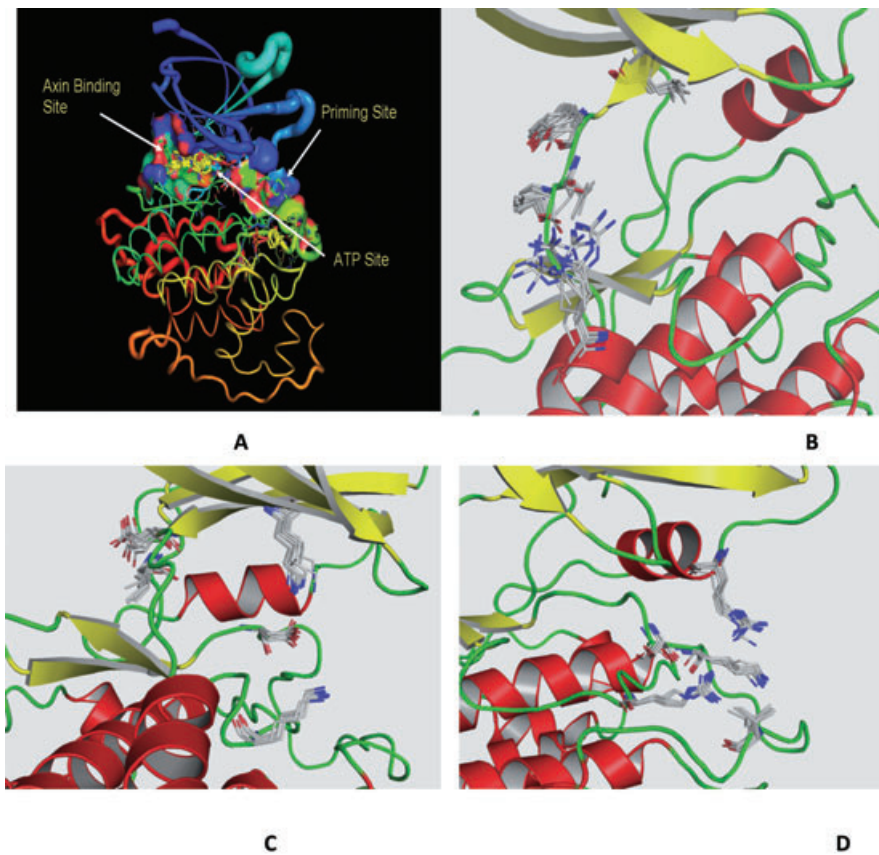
Different binding pockets of GSK3 β . (A) Overlay of X-ray structures at C α depicting different binding sites for GSK3 β ; (B) ATP site; (C) axin binding site; (D) priming site. The residues of each site are overlaid to understand the mobility of each residue. The helices are denoted in red, β -sheets in yellow and loops in green colour. The residues are shown in elemental colours. GSK3 β , glycogen synthase kinase-3 beta.
